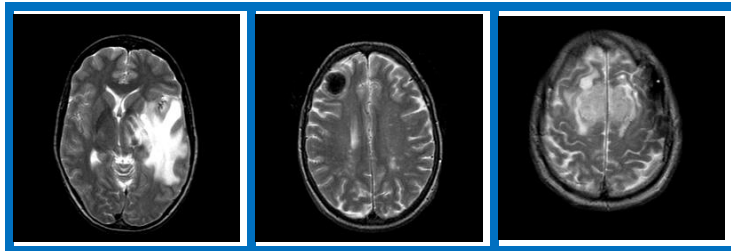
Examples of MRI human brain diseases [40].
